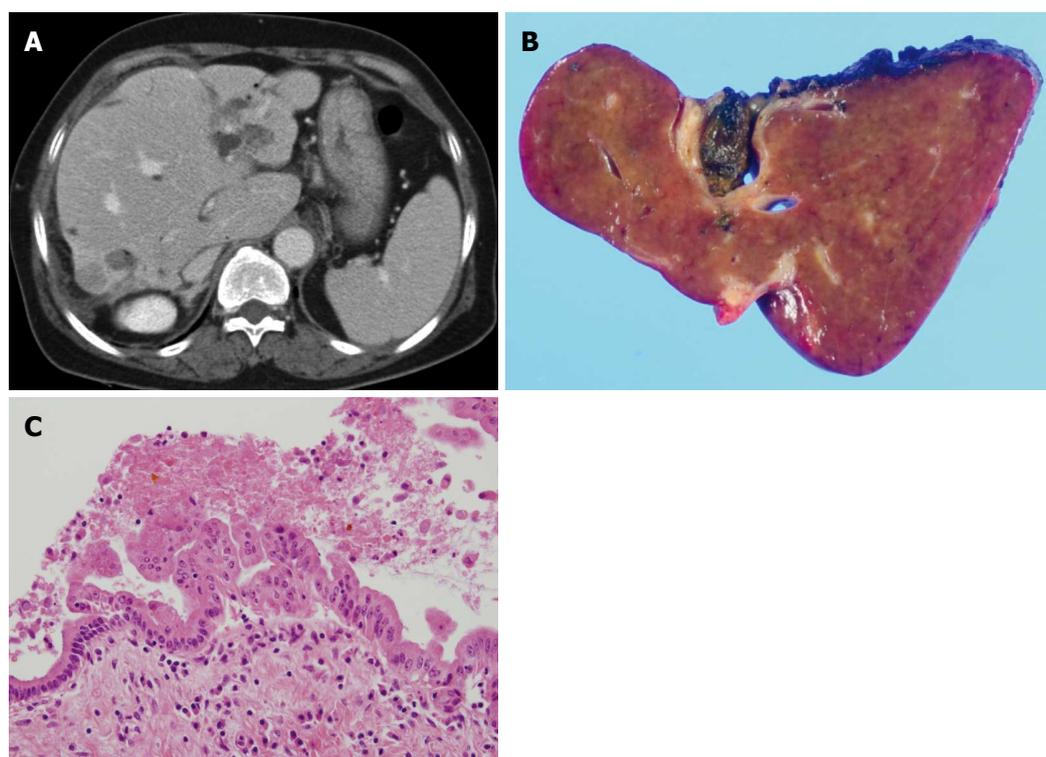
Sixty-seven years old, female was admitted for cholangitis and treated with hepatic resection. She was followed and underwent second resection 1 year later. A: Abdominal computed tomography demonstrated that B2 IHD dilatation with stones and 2 cm sized low density lesion in liver S7; B: Liver, left, lateral, segmentectomy was done; C: BillIN1 and two were shown on dilated duct with glandular proliferation.
